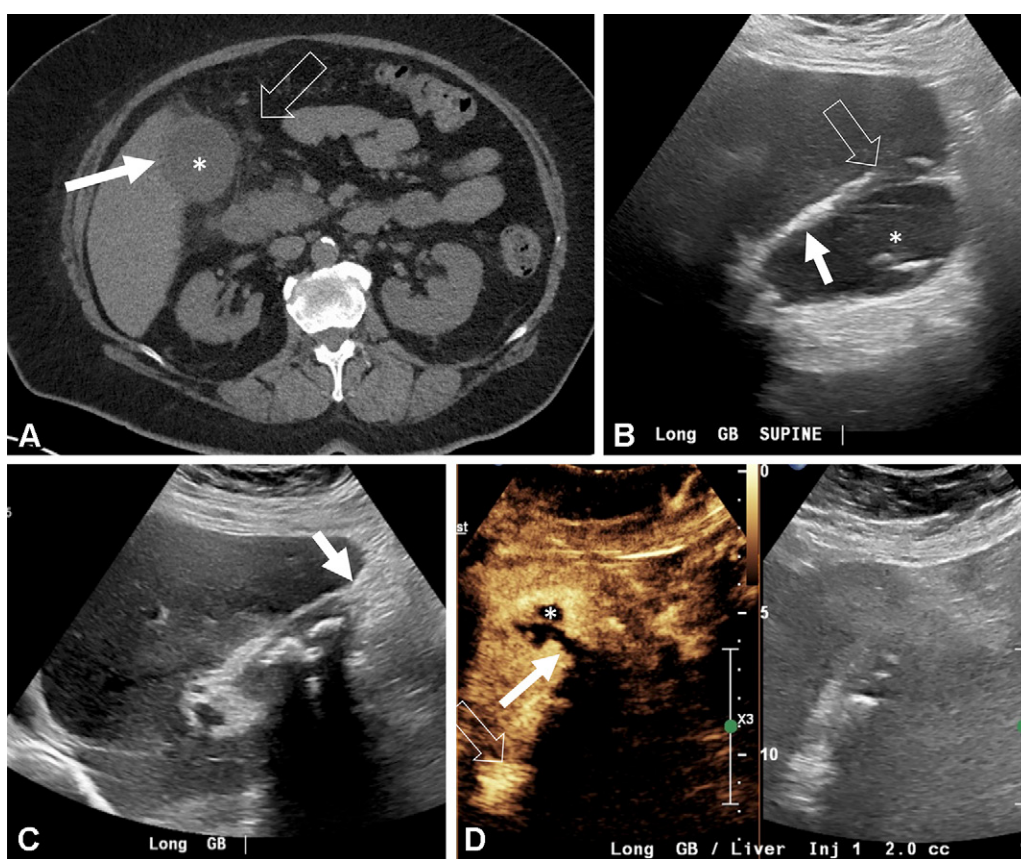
Cholecystitis confirmed with CEUS in a 58-year-old woman with epigastric pain. (A) Axial noncontrast CT image shows the gallbladder (*) with wall thickening (solid arrow) and pericholecystic stranding (open arrow). (B) Gray-scale US image shows a stone-filled gallbladder (*) that is not overtly dilated with wall thickening (solid arrow) and areas of wall heterogeneity (open arrow). (C) US image shows echogenic pericholecystic fat (arrow) adjacent to the gallbladder fundus, suggesting transmural inflammation, a sonographic correlate for the pericholecystic stranding seen at CT. (D) CEUS (left) and gray-scale (right) US images show a frank defect (solid arrow) in the gallbladder wall, a small intrahepatic abscess (*), and pericholecystic hyperemia (open arrow). (Case courtesy of Razan Noorelahi, MD, and David Fetzer, MD, University of Texas Southwestern.)
